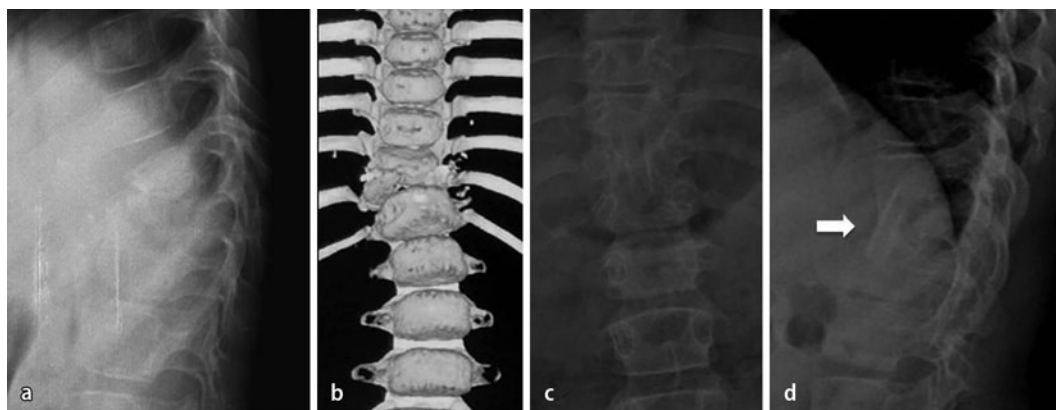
▲ Anterior radical excision surgery for spinal tuberculosis. a Lateral radiograph and b coronal CT of thoracolumbar spine showing destruction of T12–L1 vertebra and kyphosis. The patient was treated by removal of infected bone, abscess, necrotic granulation tissue, and reconstruction with fibular strut grafts (*white arrow*) as seen in the anteroposterior and lateral postoperative radiographs (c, d)
